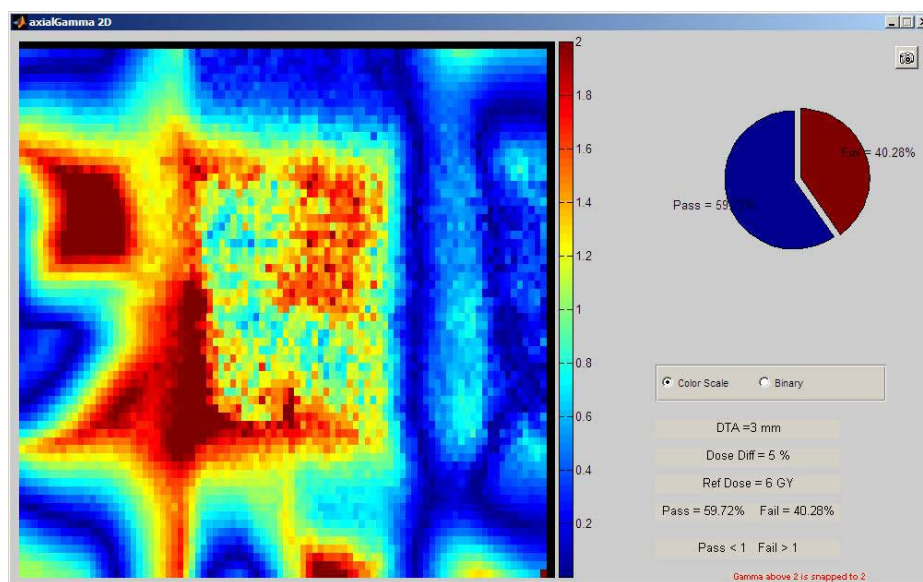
Plan 1a Trial 2 Axial Gamma Analysis with PVC Shell contoured and CT Number set to match Eclipse Calibration Curve
